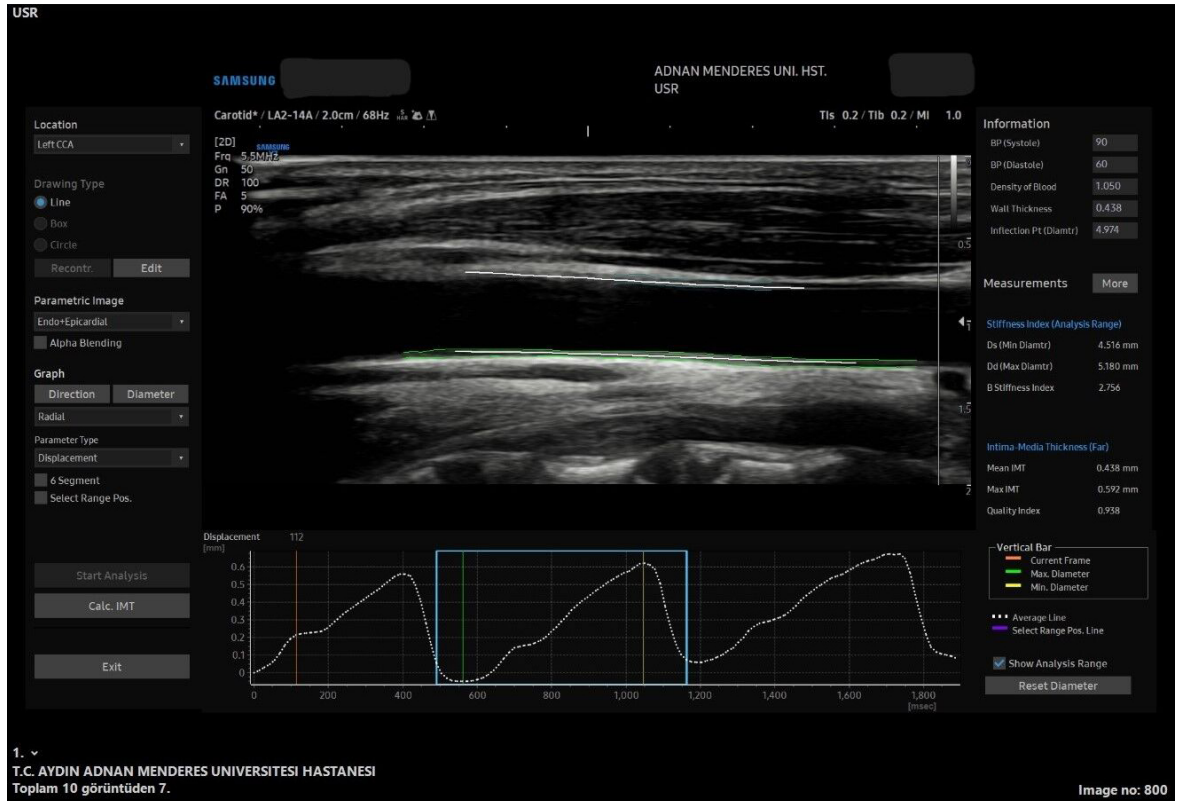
All stiffness and strain measurements in the speckle tracking carotid strain (STCS) software in the axial plane. Wave forms and the axial US image captured for the arterial analysis (a), all the measurements that was obtained from the soft-ware from that US wave form image (b). 2D, 2 Dimension; BP, blood pressure; Ds, diameter in systole; Dd, diameter in diastole; CCA, common carotis artery; US, ultrasonography.
